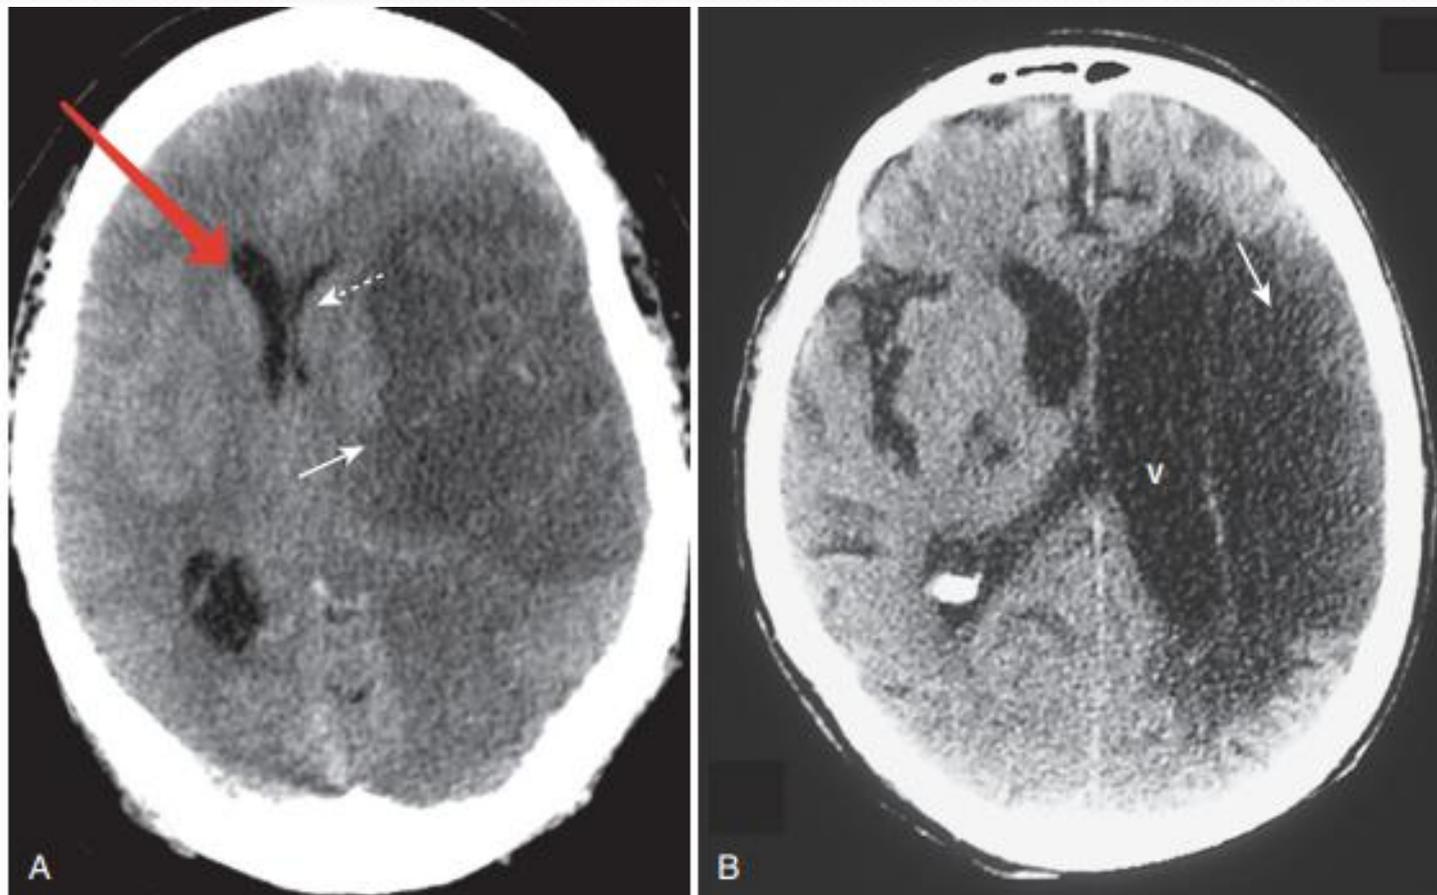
Computed tomography, ischemic stroke, newer and older. The findings in ischemic stroke will depend on the amount of time that has elapsed since the original event. A, At about 24 hours, the lesion becomes relatively well circumscribed (solid white arrow) with mass effect evidenced by a shift of the ventricles (dotted white arrow) that peaks at 3 to 5 days and disappears by about 2 to 4 weeks. B, As the stroke matures, it loses its mass effect, tends to become an even more sharply margined low-attenuation lesion (solid white arrow), and may be associated with enlargement of the adjacent ventricle (V) due to loss of brain substance in the infarcted area.
